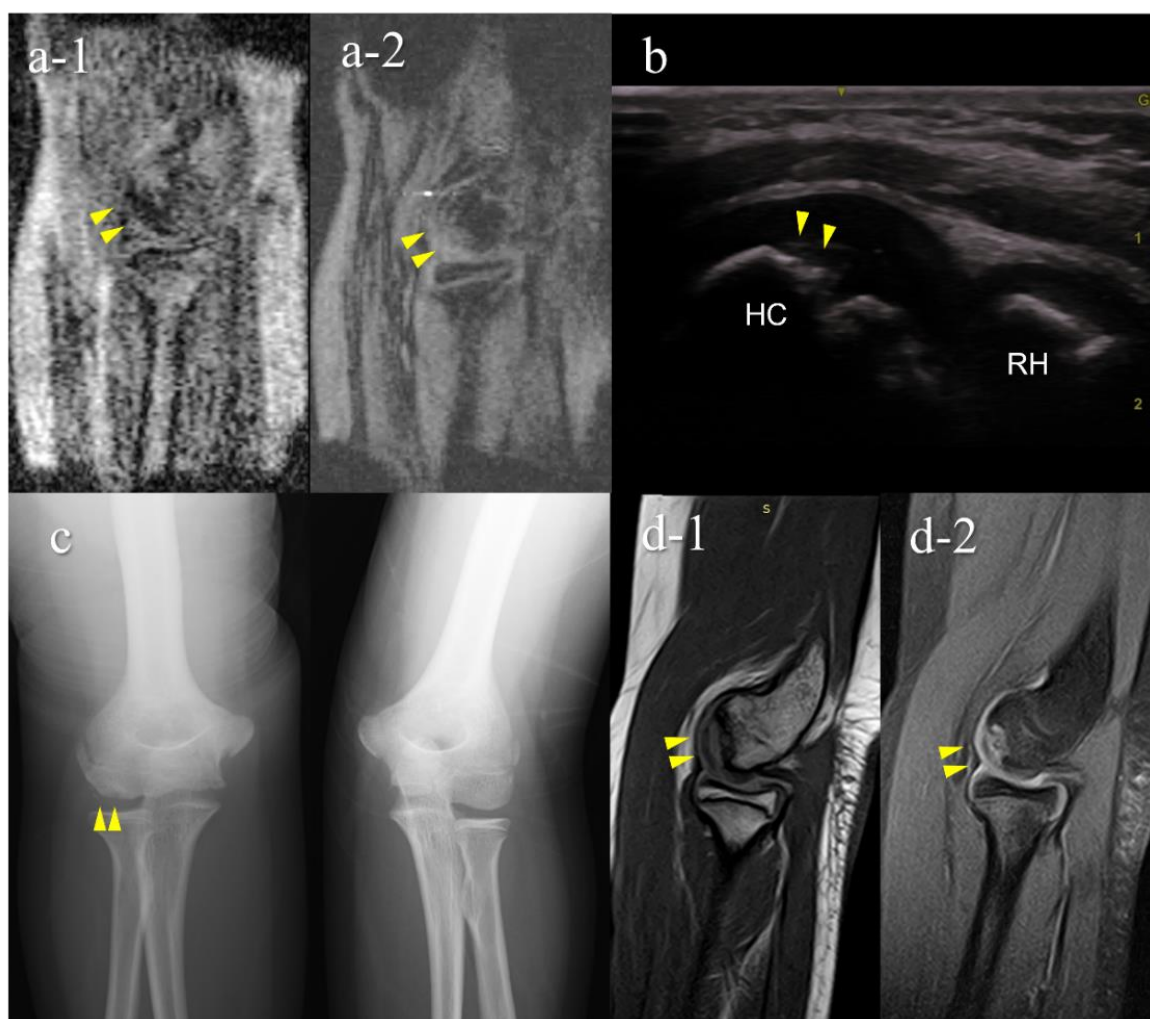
A false-negative OCD case with mobile MRI (Case 1): Mobile MRI (−), US (+). (a) Mobile MR (magnetic resonance) images: a-1, T1WI sagittal image; a-2, T2*WI sagittal image: Mobile MRI with poor imaging quality with low signal/noise ratio. Although the signal change was barely visible from the anterior to the humeral capitellum, we could not detect it; (b) US image of the posterior longitudinal view: US imaging revealed obvious subchondral bone irregularity; (c) X-p AP view with elbow 45° flexed: X-p 45° showing the lesion with fragmentation in the central capitellum, stage II OCD; (d) 3T MR images: d-1, proton density-weighted images (PDWI) sagittal image; d-2, PDWI-fat-suppressed (FS) sagittal image: 3T MRI easily detected the lesion. HC, humeral capitellum; RH, radial head; yellow arrowheads, lesions.
